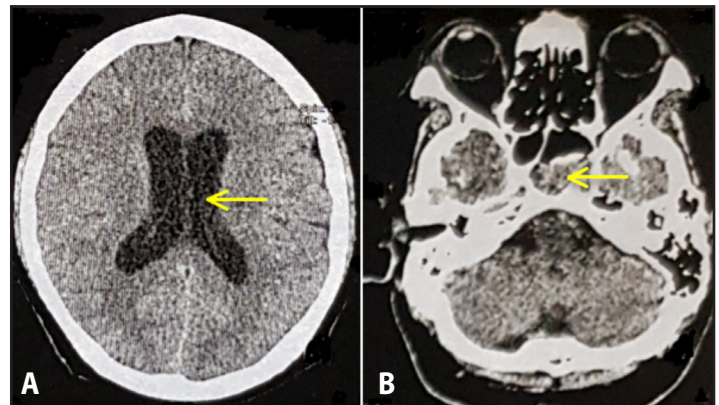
Plain Cranial CT Scan. A. Non-communicating hydrocephalus (arrow). B. Polysinusitis involving the sphenoid (arrow).
